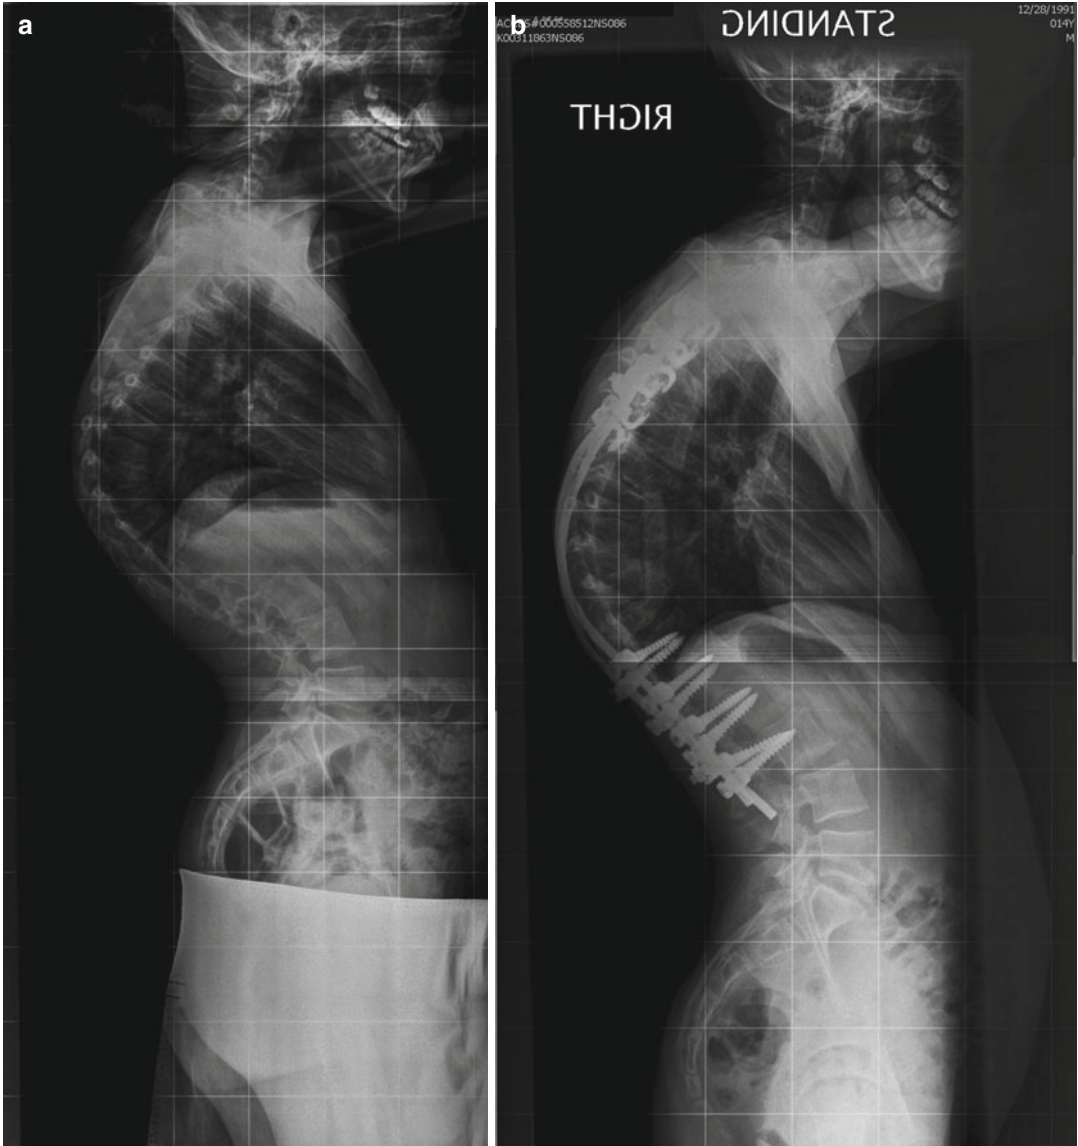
A 13-year-old boy who was treated as a toddler with laminectomy and radiation for a Ewing's sarcoma. (a) Standing lateral radiograph demonstrating 90° of thoracic kyphosis. (b, c) Standing lateral radiograph
